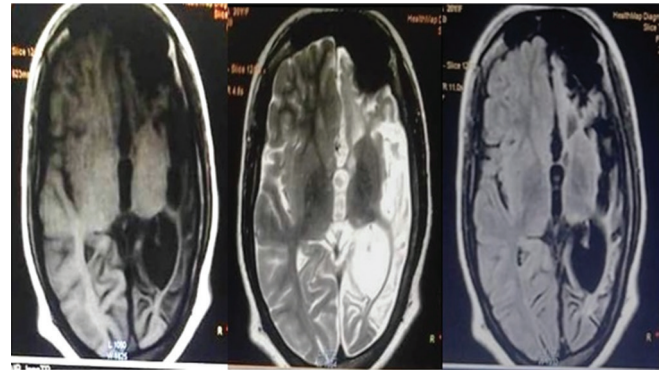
Axial magnetic resonance imaging brain T1, T2, T2-fluid attenuation inversion recovery (FLAIR) sequences. *Images showing left cerebral hemispheric cortical atrophy with encephalomalacia which is hypointensities on T1 and hyperintensities on T2 and T2 FLAIR with ex vacuo dilation of lateral ventricle with left-sided calvarial thickening and left side hyperpneumatization of the left frontal sinus
